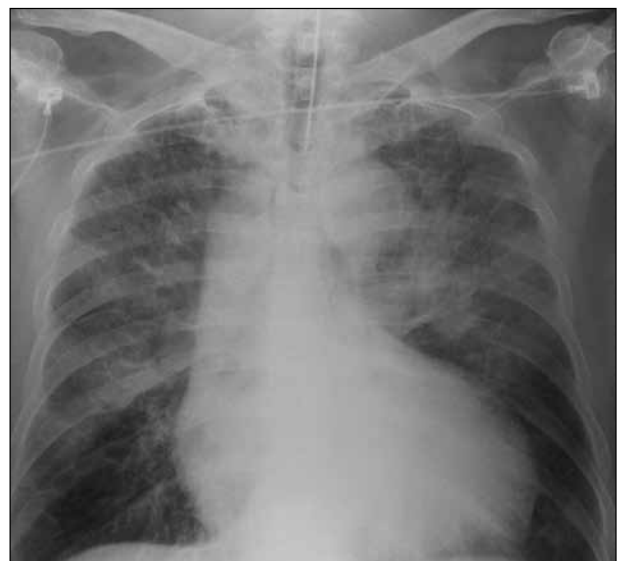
Chest radiograph shows bilateral upper lobe diversion associated with acute pulmonary oedema and cardiomegaly.
